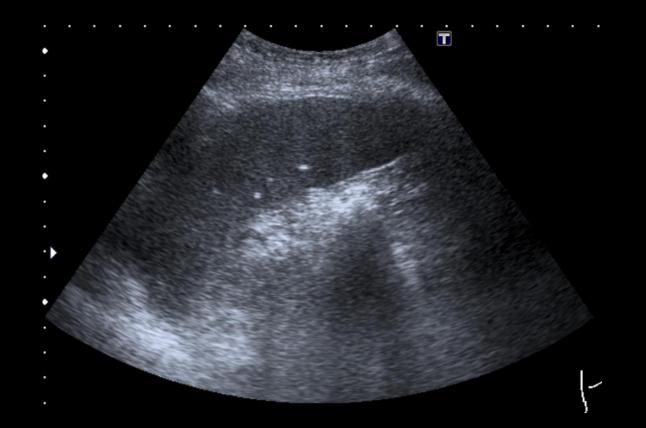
Ultrasound. Calcified Granulomas. A usual finding in granulomatous diseases.
